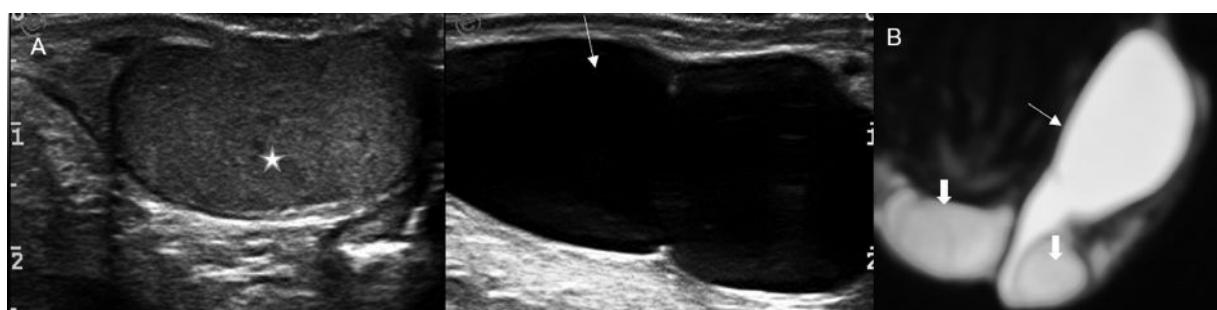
(A) Spermatic cord cyst: Split screen gray scale US shows the normal testis (*) and an oblong cystic lesion (thin arrow) along the course of the left spermatic cord. (B) Coronal T2W MRI image shows hyperintense left spermatic cord cyst (thin arrow) arising from the lower pole of the left testis, extending superiorly between the two normal testes (thick arrows).*
